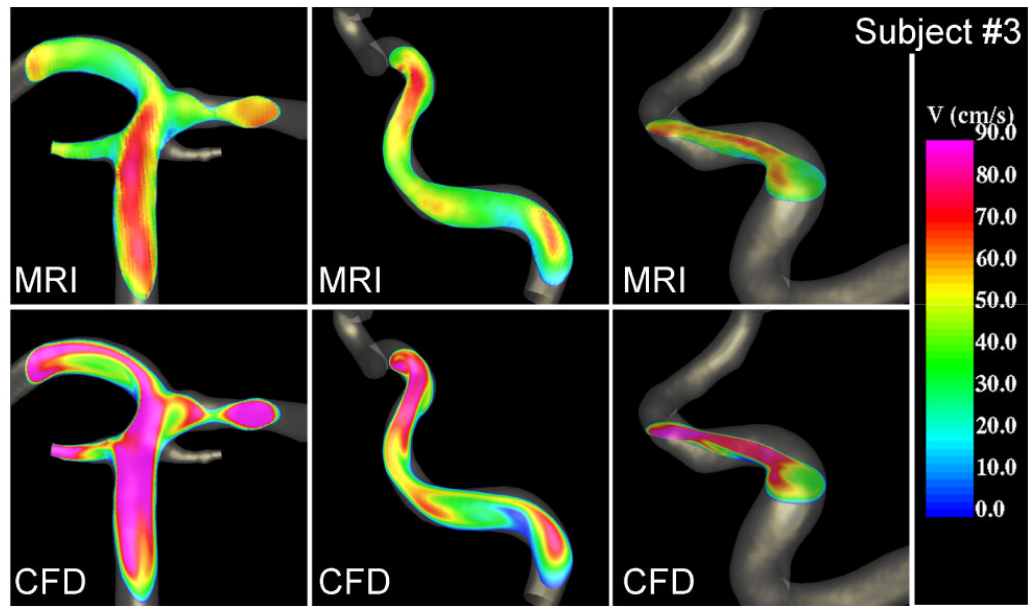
Velocity profiles at peak systole in the basilar (left), the right (center) and left (right) internal carotid arteries of subject #3 obtained from the MRI (phase-contrast MR) data and CFD model.
